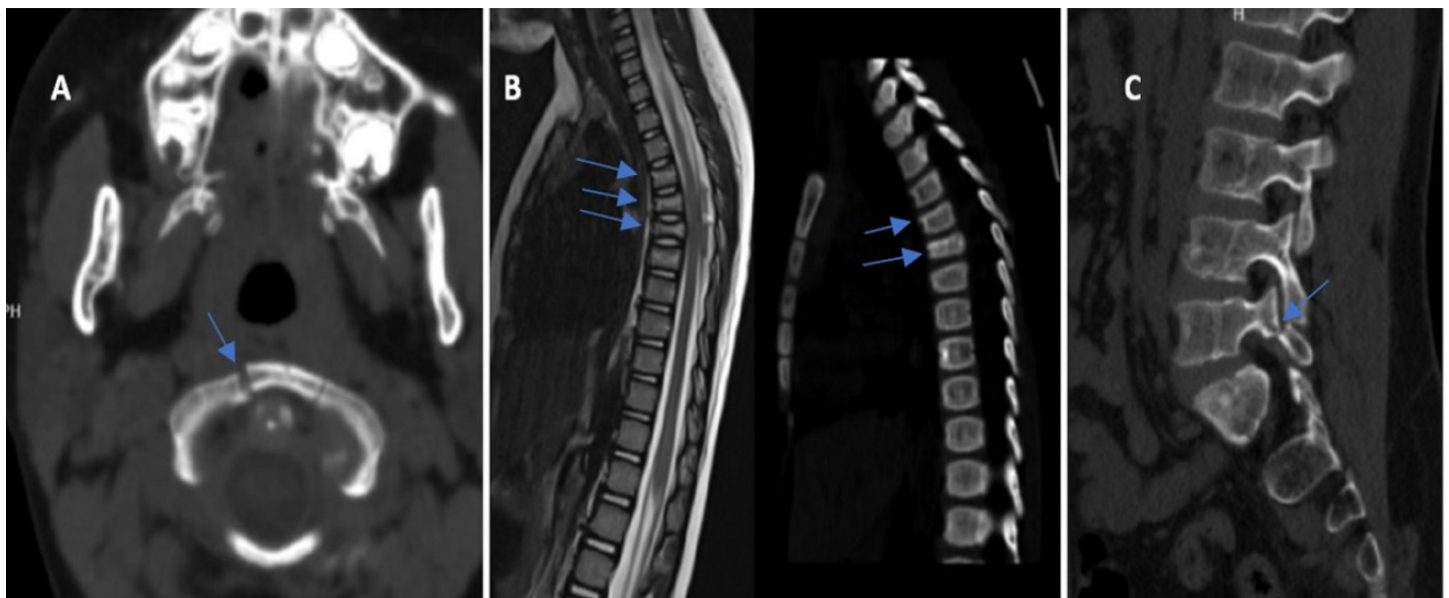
Spinal injuries due to trauma, (A) axial CT image reveals the cranial suture separation of C1 anterior occurs due to fall at age 4, (B) sagittal T2W MRI and sagittal CT images show T5-6 compression fracture due to fall at age 8, (C) L5-S1 Pars fracture due to in-vehicle traffic accident is seen on sagittal CT image
